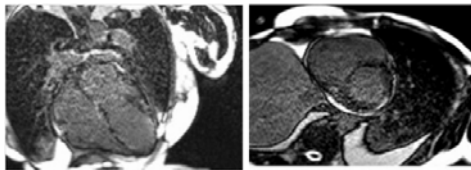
Delayed enhancement on MRI
